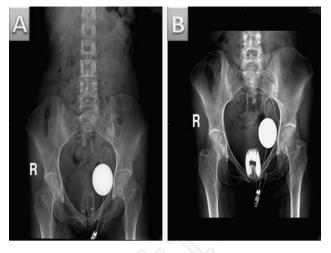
Abdominal x-ray of Acticon* neosphincters in situ showing: A) at rest, and B) in closed status.
